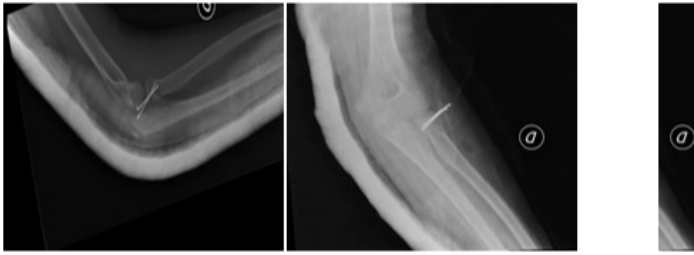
Postoperative anteroposterior and lateral radiographs of the right elbow. The anatomical situation of the radial head (fixed with two Kirschner wires) can be seen.
